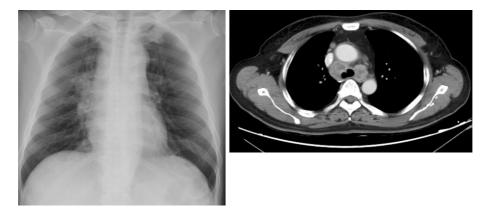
Chest X-ray and CT performed 2 two months after the initiation of anti-tuberculosis therapy. Chest X-ray and CT scan demonstrated exacerbated mediastinal lymphadenopathy.
